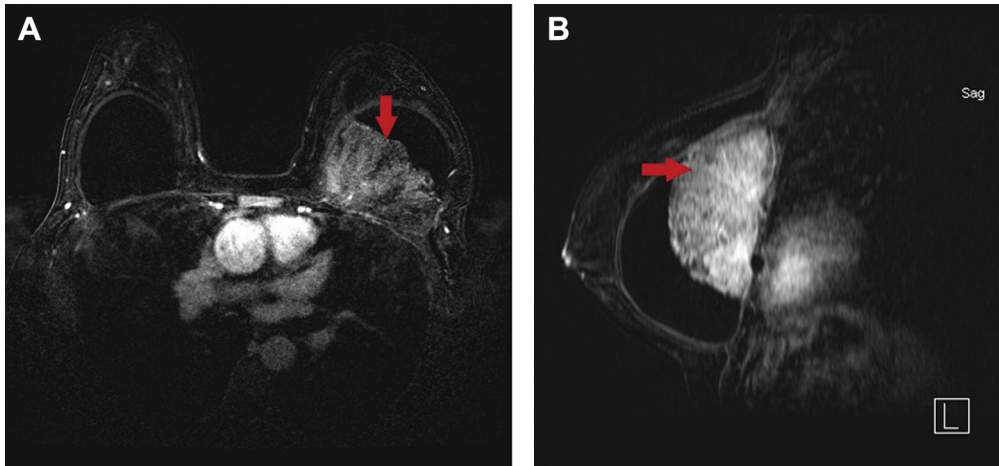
(A) Axial and (B) sagittal T2 fat-saturated postcontrast images from a contrast-enhanced bilateral breast MRI demonstrates a 5.8 cm × 8.5 cm × 11.2 cm hyperintense mass with fringe-like appearance (red arrow) posteromedial to the left breast implant.
